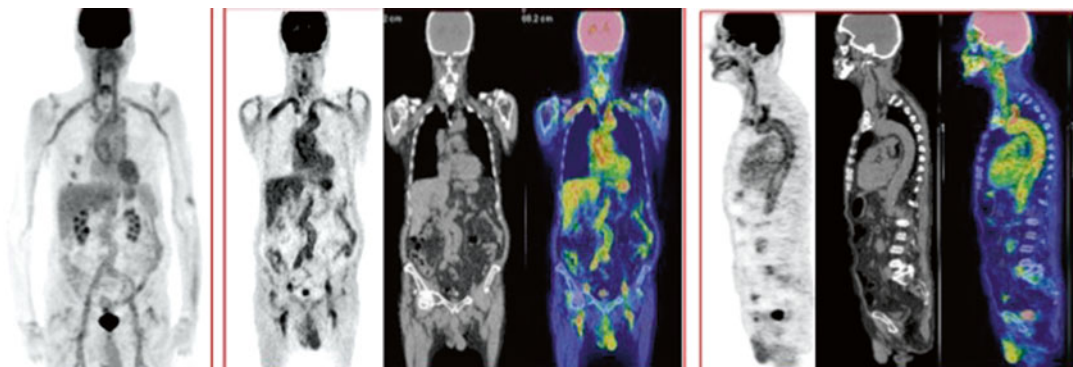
Example of the pattern of [^{18}F]FDG uptake in a patient with large vessel vasculitis. Intense linear uptake along the wall of the aorta and epi-aortic vessel is present and allowed to define the extent of the disease (Courtesy of Annibale Versari)
